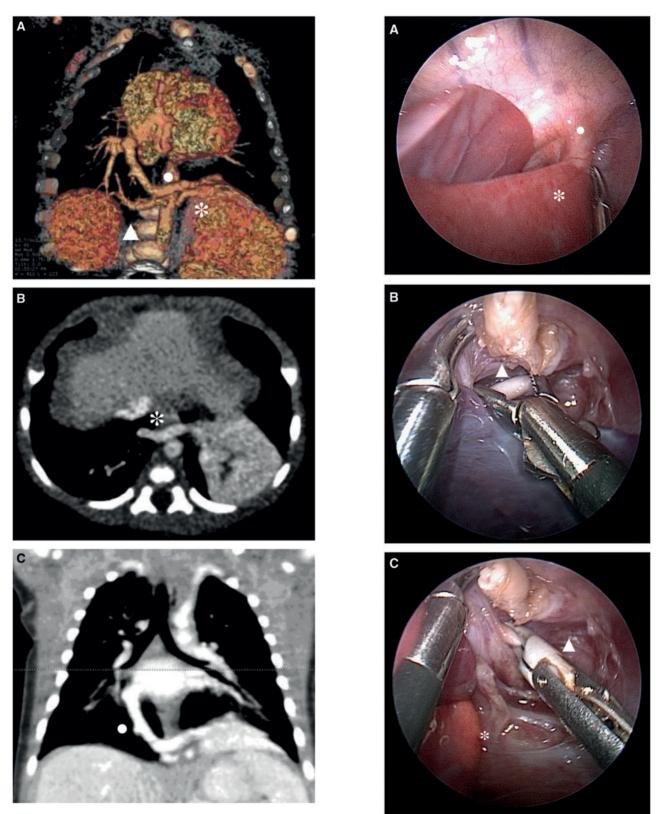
(A) Magnetic resonance imaging: *, arterial; •, venous vessels of the sequestration and ▲, aorto-to-pulmonary vein fistula. (B) An angiocomputed tomography scan: *, the aortic origin of the 2 arterial branches. (C) An angiocomputed tomography scan: •, venous drainage of the sequestration.
